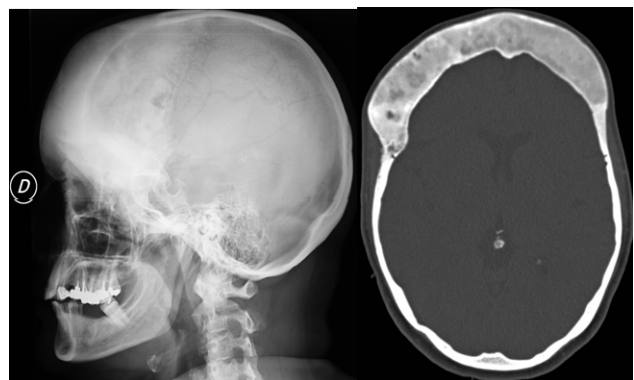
Skull x-ray profile view (left). Skull CT bone window (right). Frontal bone condensed type fibrous dysplasia
